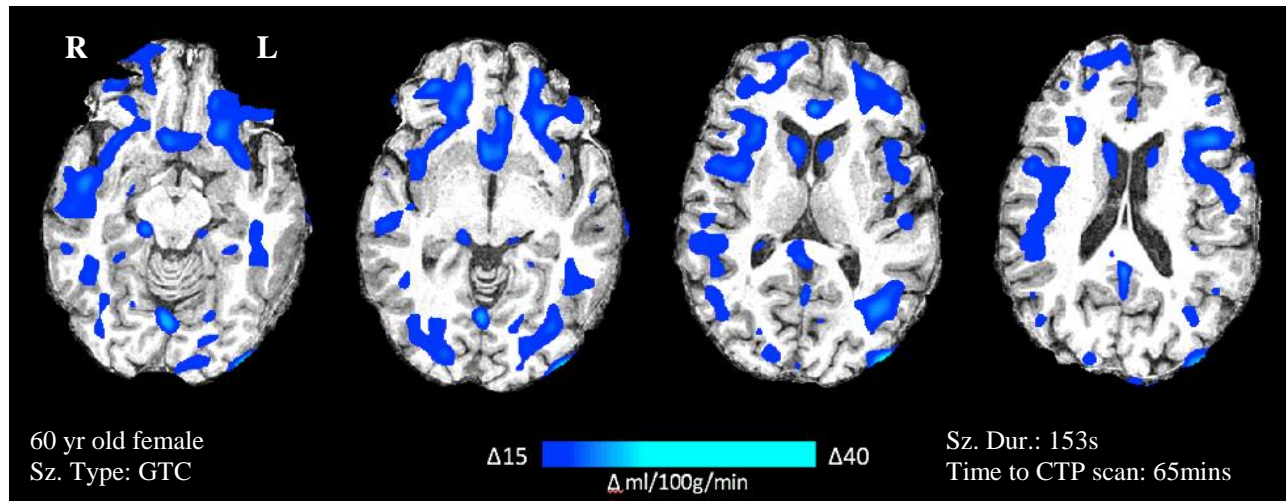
Example of global hypoperfusion seen on sCTP through comparing a patient's postictal CTP CBF maps to baseline ASL maps obtained from 100 healthy controls. Data are shown for Patient 4 and are superimposed on T1-weighted images.
